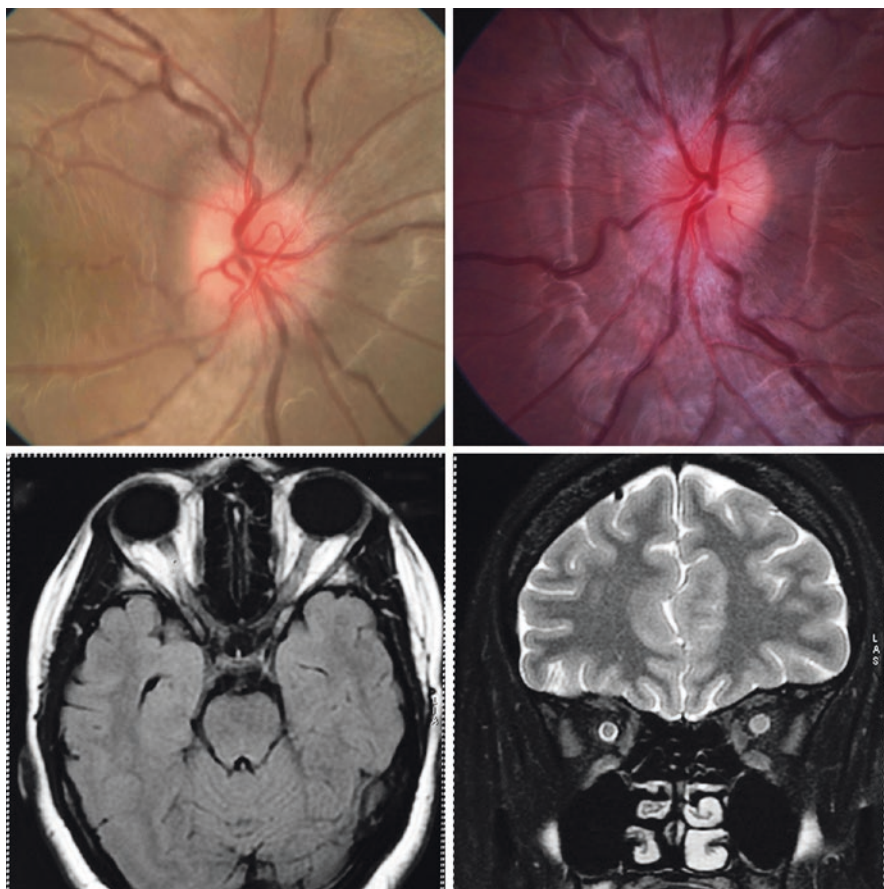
A child with bilateral optic neuritis—the top panel shows bilateral optic disc swelling. The bottom panel shows imaging findings—MRI T2 FLAIR axial scan (bottom right) and T2-weighted coronal scan (bottom left) showing hyperintensities in both optic nerves
